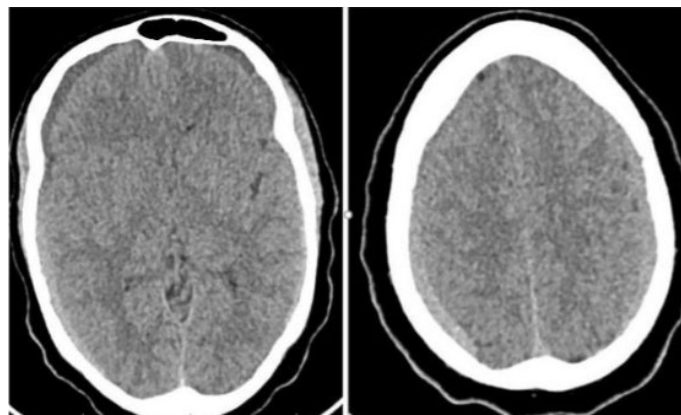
Non-contrast CT scan of the brain showing an isodense, extra-axial collection is seen overlying bilateral frontal-parietal lobes (right 0.7 cm thick, left 0.5 cm thick) midline central. Effacement of adjacent cortical sulci as well as anterior horn of the right lateral ventricle.
